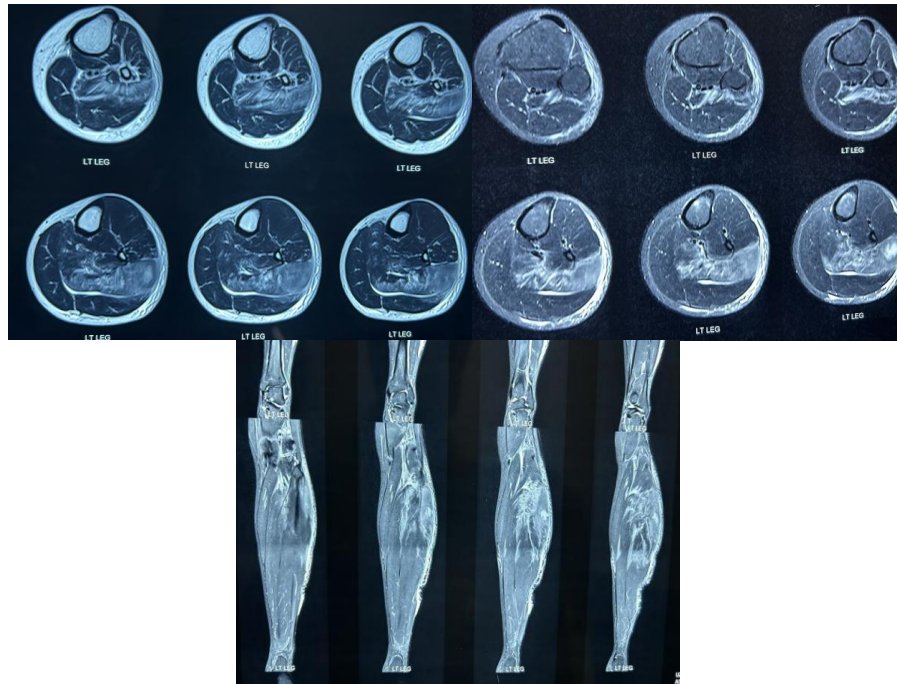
MRI left calf showing edematous changes, myositis and pockets of free fluid involving the tibialis posterior, soleus muscle and lateral head of gastrocnemius muscle suggestive of cellulitis or abscess.
